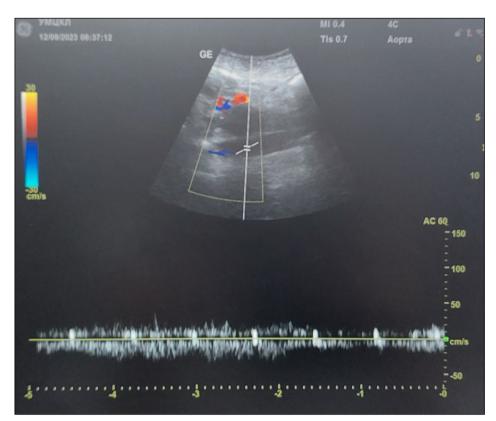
Ultrasound examination: venous blood flow spectrum in the IVC 1.5 years after cavaplication is not disturbed *Picture taken by the authors*
